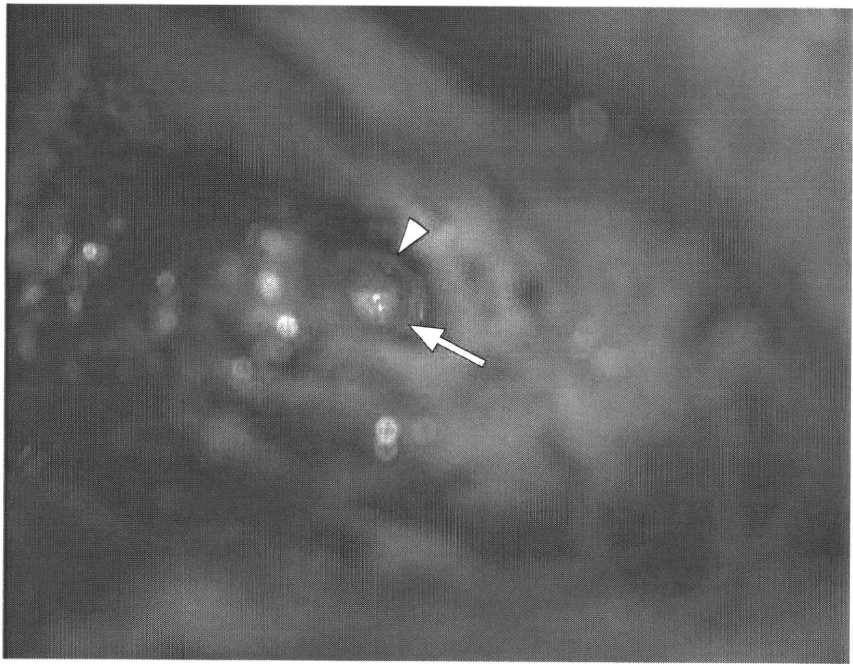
Intraoperative findings of a cochlear implantation surgery in the right ear. The inferior portion of the basal turn of the cochlea was totally ossified, although the preoperative MRI showed a narrow but patent cochlea. Note that the color of the scala tympani (arrow) and scala vestibuli (arrowhead) is different as a result of the different degrees of ossification.
